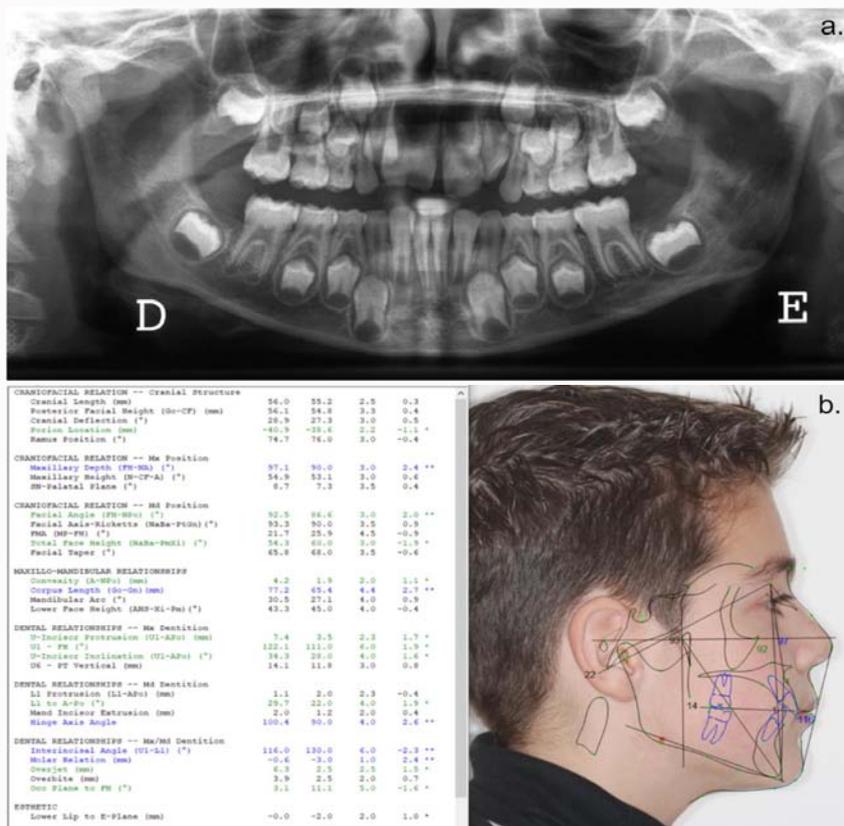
Panoramic radiograph (a) and cephalometric tracing (b).
